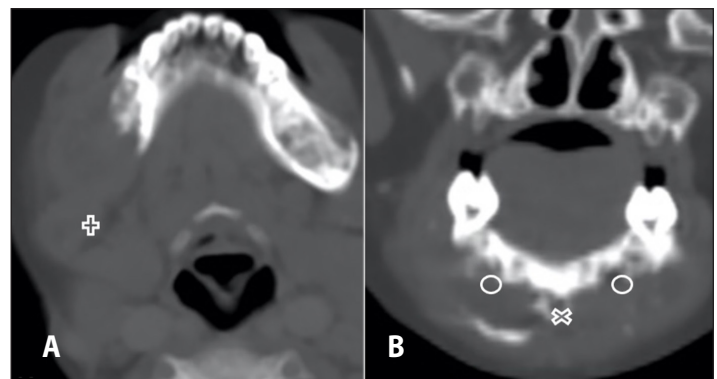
Head CT with contrast, A. axial and B. coronal bone window cuts showing peripherally enhancing hypodense mass with lytic expansion involving the right angle (+), symphysis (X), bilateral parasymphysis and bilateral mandibular body (O); C. 3D reconstruction showing lytic expansion involving the right mandibular angle, symphysis, bilateral parasymphysis and bilateral mandibular body.
